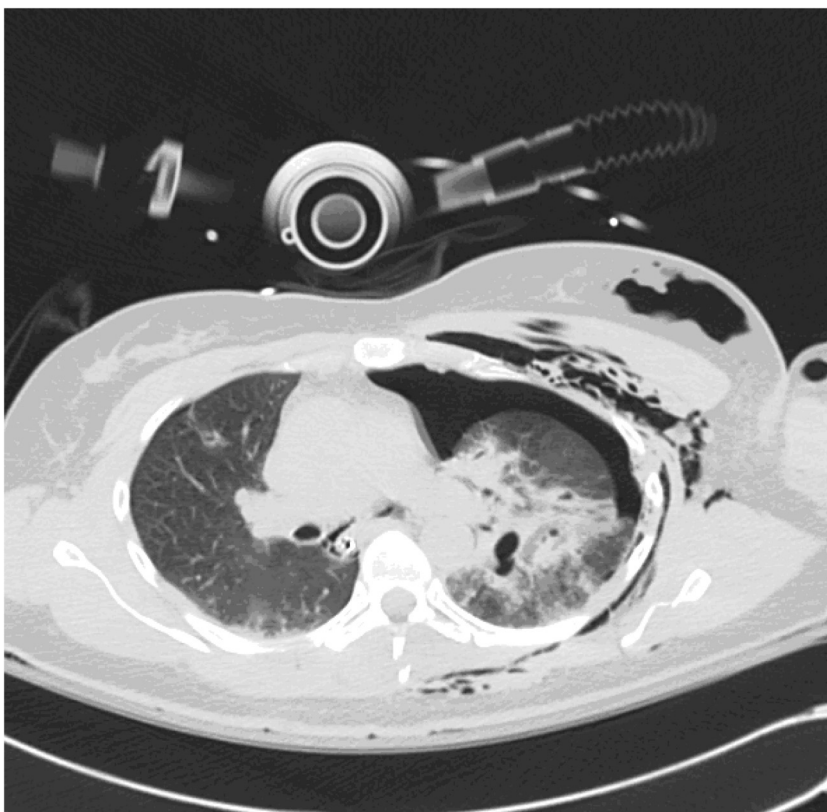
Axial view of her CT scan demonstrating left pneumothorax, and soft tissue emphysema.
